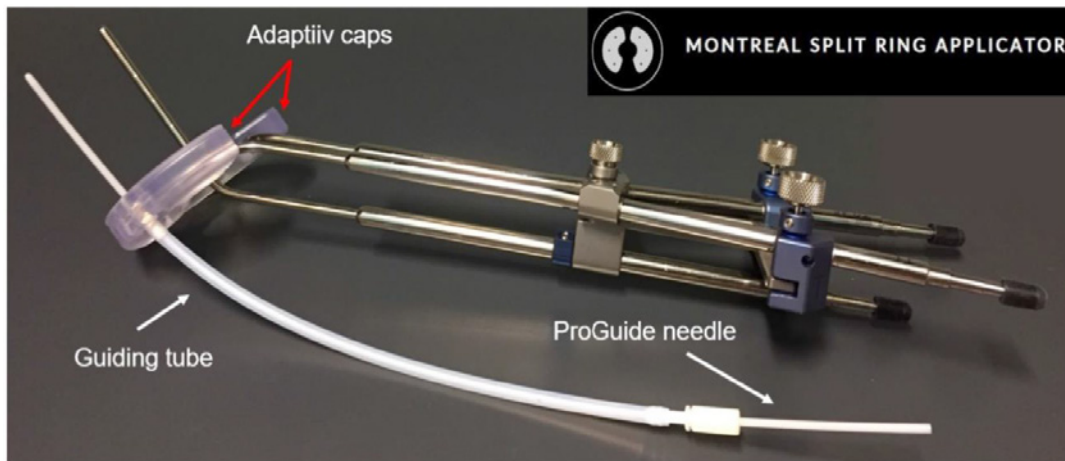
The Montreal split ring applicator assembled using the CT/MR split ring IC applicator, a Venezia guiding tube, and a ProGuide IS needle as well as Adaptiiv caps that were 3D-printed using BioMed Clear resin
